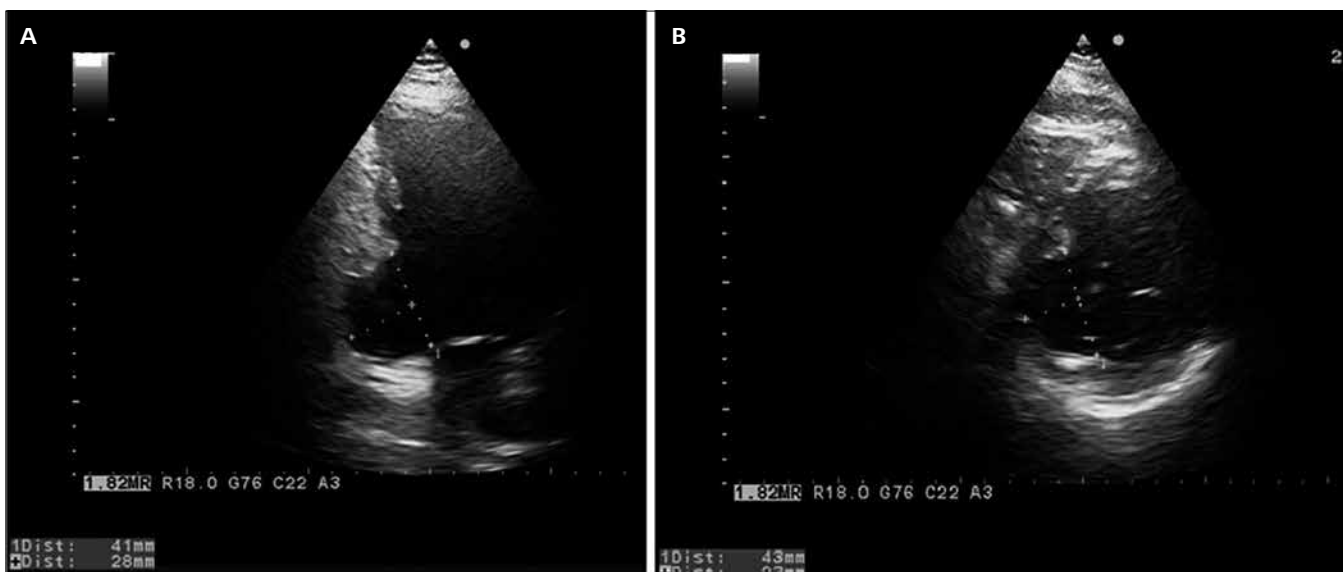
Transthoracic echocardiography. A. Apical 2-chamber view. B. Parasternal short axis view. Inferior wall aneurysm. Neck diameter – 41 mm; longitudinal axis of aneurysm cavity – 28 mm
